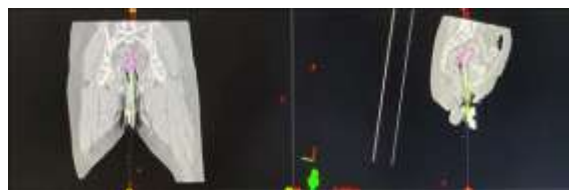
Representative BrachyVision CT-based plan showing applicator reconstruction and a pear-shaped isodose distribution.
